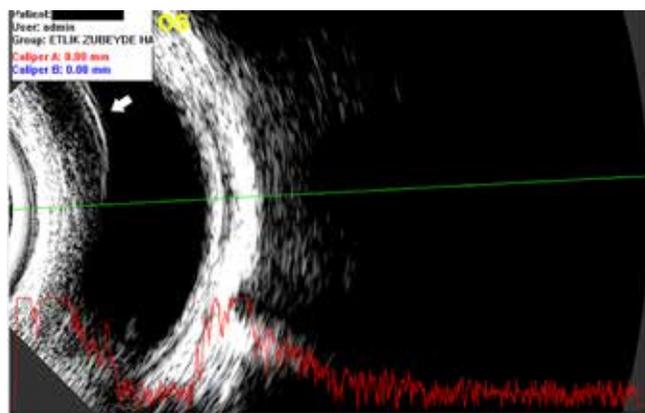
B-scan ultrasonography of the patient's left eye showing an enlarged lens extending into the anterior vitreous (white arrow) and no definitive retinal detachment.
